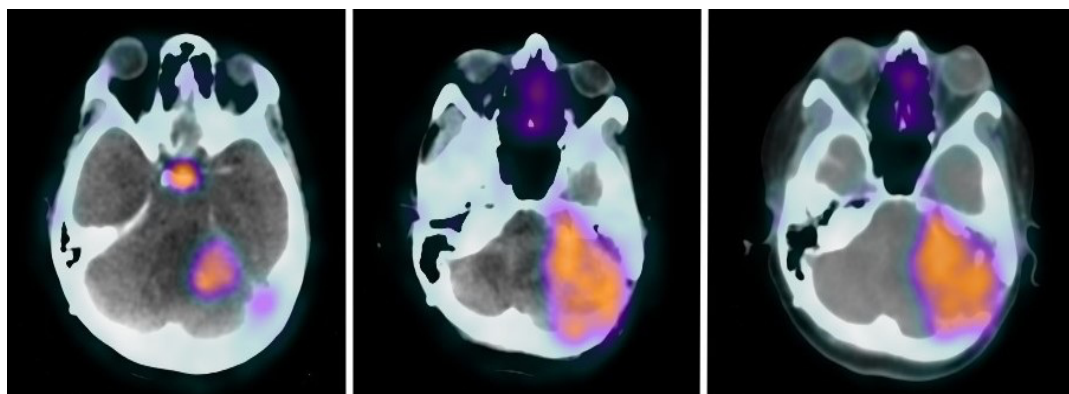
Ga-68 labeled DOTATATE PET/CT scan shows uptake in the area of the left cerebellar hemisphere.
